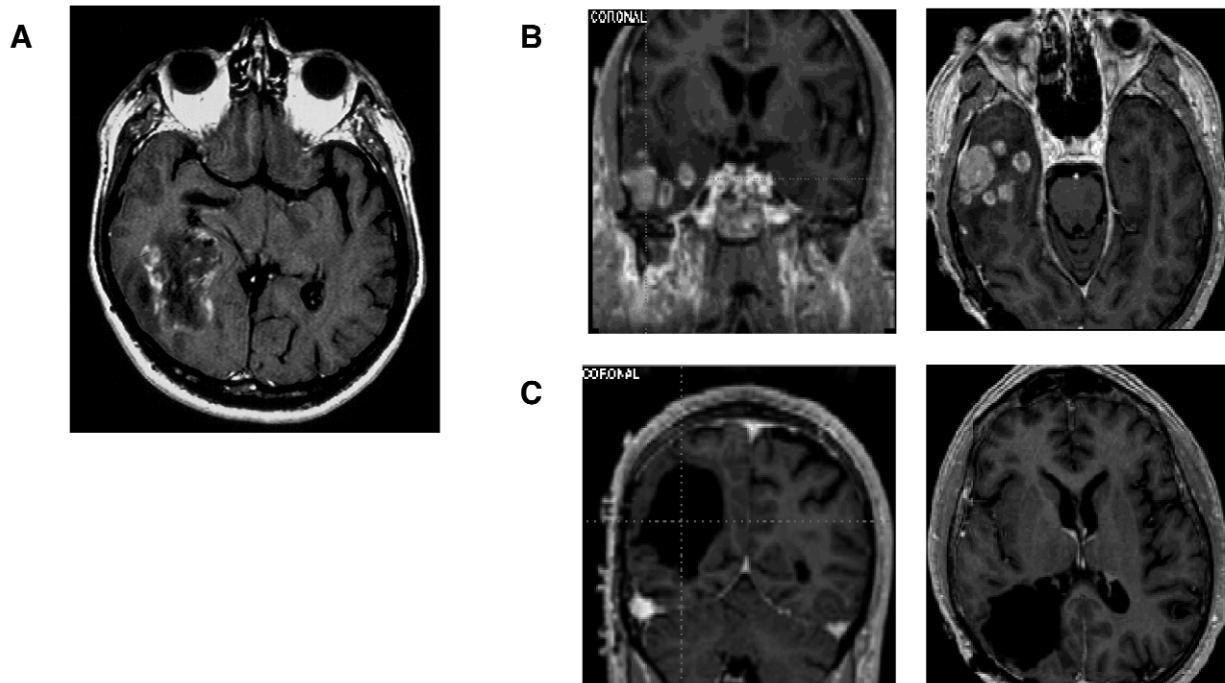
A. T1-weighted MRI examinations of the first tumor. A gadolinium-enhanced lesion in the right parieto-occipital lobes with necrosis areas and edema is shown. B, C. Gadolinium enhanced T1-weighted MRI scans of the second GBM (B) showing a right temporal tumor 5 years after the resection of the first GBM (C). A local re-growth of the first tumor was not found.
